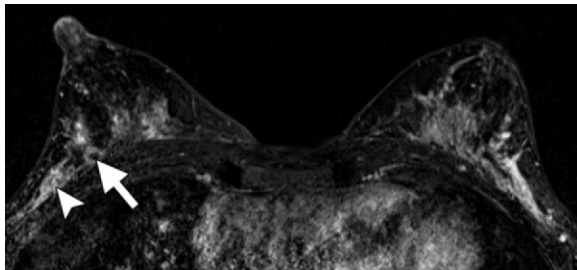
Potential false-negative interpretation due to marked BPE in a 38-year-old woman with newly diagnosed cancer in the right breast. Four subcentimeter malignant masses (one palpable) were visible in the 8:30 to 9-o'clock position at US (not shown). Axial contrast-enhanced T1-weighted fat-suppressed MR subtraction image shows marked BPE; known malignant lesions are difficult to perceive against BPE. A biopsy clip (arrow) marks one of the lesions. The arrowhead marks another extremely subtle lesion within the lateral BPE; this lesion would have been missed if the MR imaging findings had not been correlated with the US findings.
